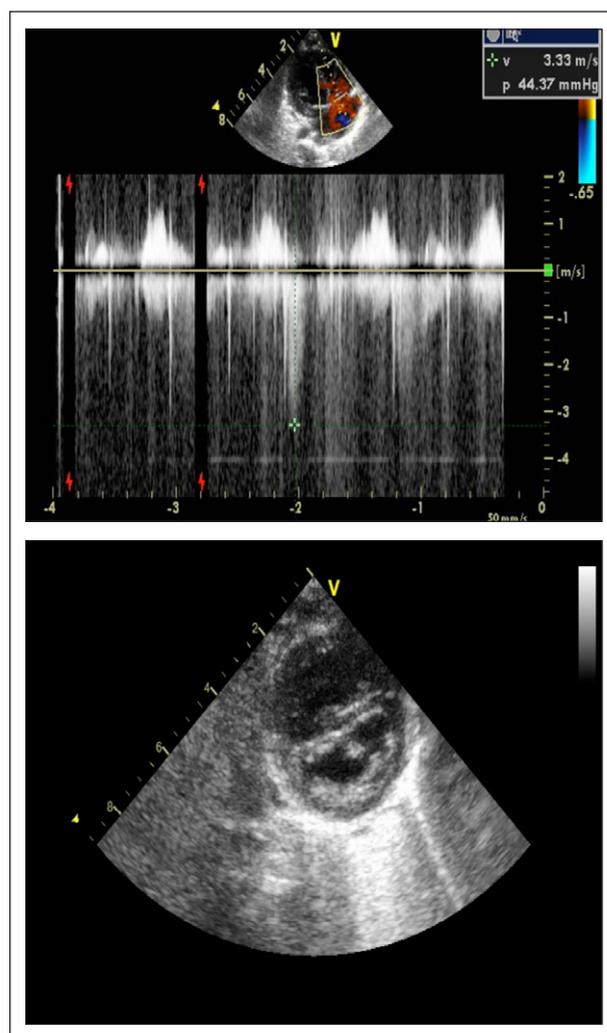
Echocardiography findings at 7 months (before sildenafil administration). Interventricular septal configuration (bowed into the left ventricle [LV] at end-systol). Maximal gradient right ventricle/right atrium was 44 mmHg. Systolic right ventricular pressure was 54 mmHg.
